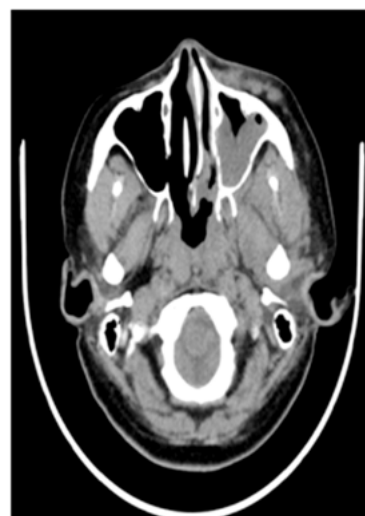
CT PNS-showing nodular thickening of mucous membranes of left nasal cavity, left ethmoidal, sphenoidal & maxillary sinus with gross dilatation and sclerosis of wall
